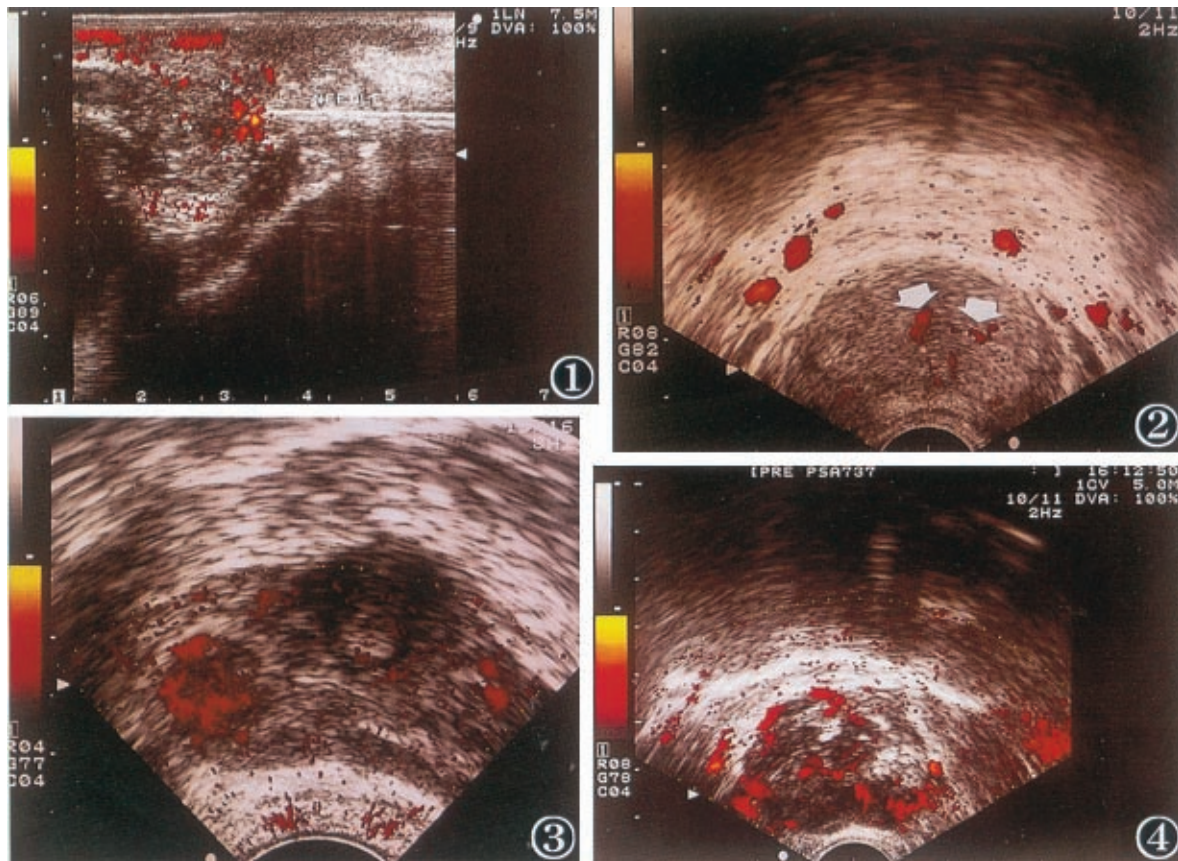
Power Doppler guided biopsy. Biopsy needle was directed to the hypervascular lesion.
